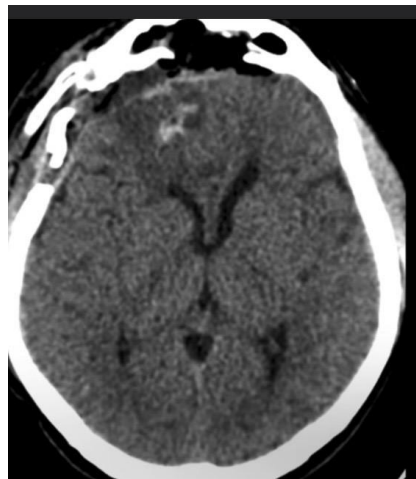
Postoperative CT scan in transversal view showed a total tumor removal
